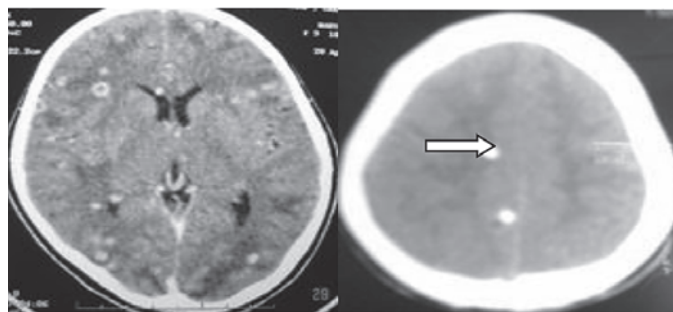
Contrast CT showing ring enhancing and disc enhancing lesions with surrounding edema Fig.13. Plain CT showing calcified granulomas
